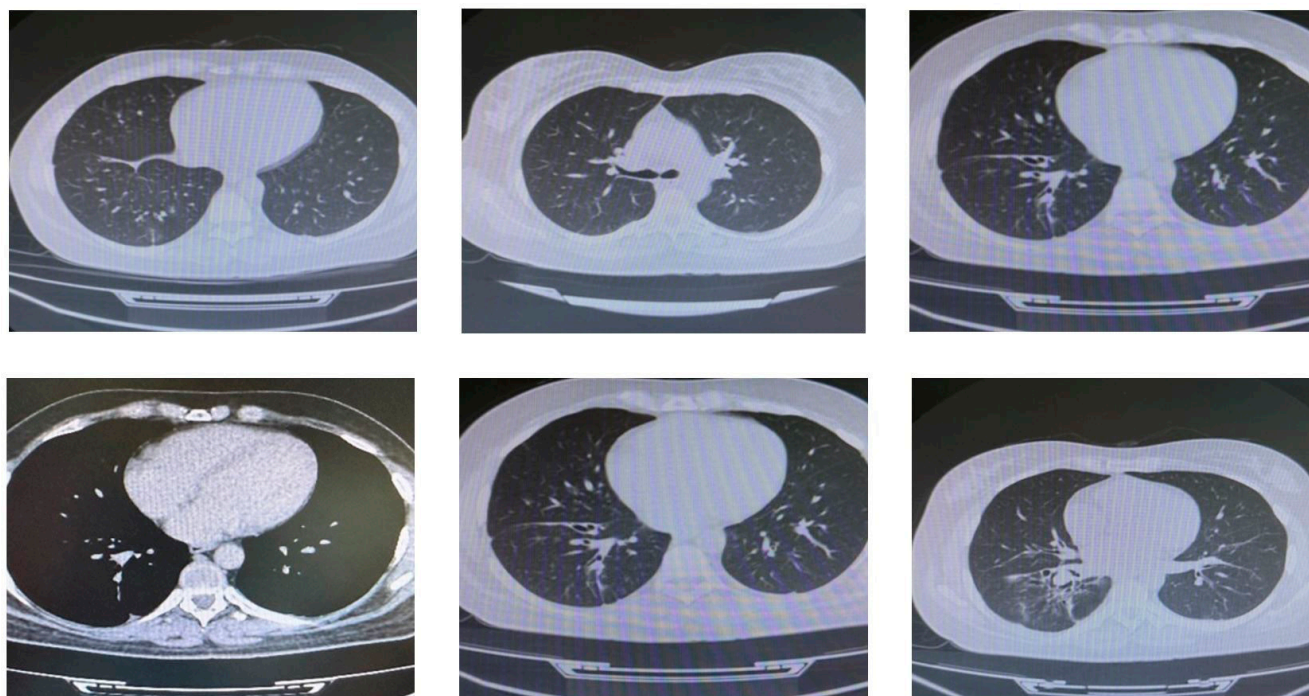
Postoperative CT scan: Right hilar lymphadenopathy (15/11 mm), nodular ground-glass opacities in left and right lungs, bronchiectasis
